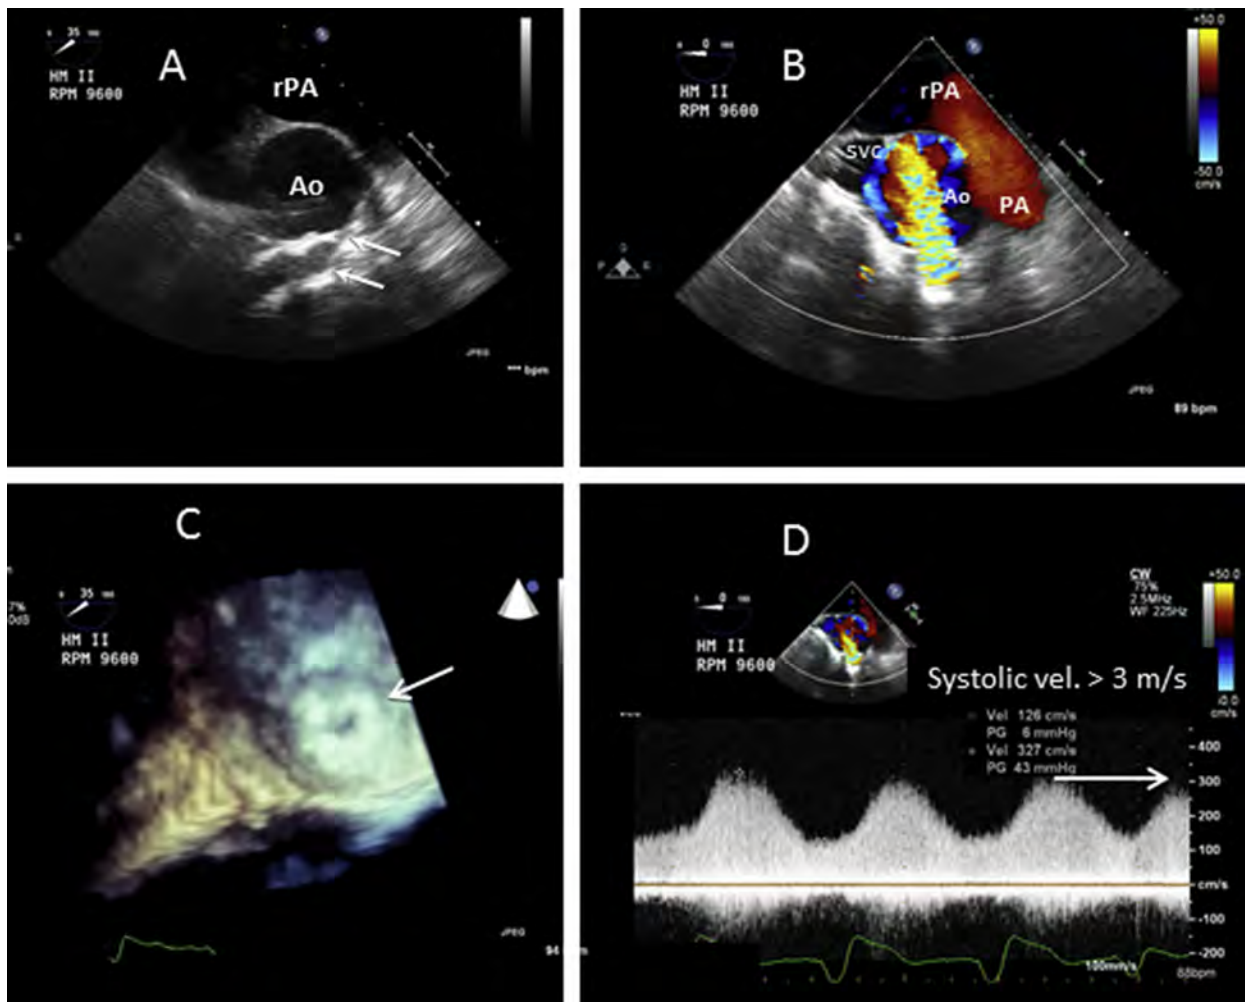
Progressive outflow-graft anastomotic obstruction identified more than 1 year after initiation of LVAD support. Increasing pump speeds were necessary for adequate LVAD flow, which was paradoxically associated with an increased, instead of a decreased, LV diameter at higher pump speeds without evidence of systemic hypertension. Pump alarms had not yet been activated. TEE, upper esophageal ascending aorta short-axis view: (A) irregular contour of the distal outflow graft (“kink” and oblique approach) with a small orifice size (arrows). See also [Video 45](#). (B) Color-Doppler flow is turbulent/aliased (compared with the normal appearance [Figs. 6A, 13C, and 13D]). See also [Video 46](#). (C) En face 3D view of the anastomosis (arrow) shows a small buttonhole orifice and suggests neointimal hyperplasia (compare with the normal appearance [Fig. 6D]). (D) Continuous-wave Doppler image with a peak systolic velocity of >3 m/s. Note that the outflow-graft anastomosis could not be visualized on TTE.
